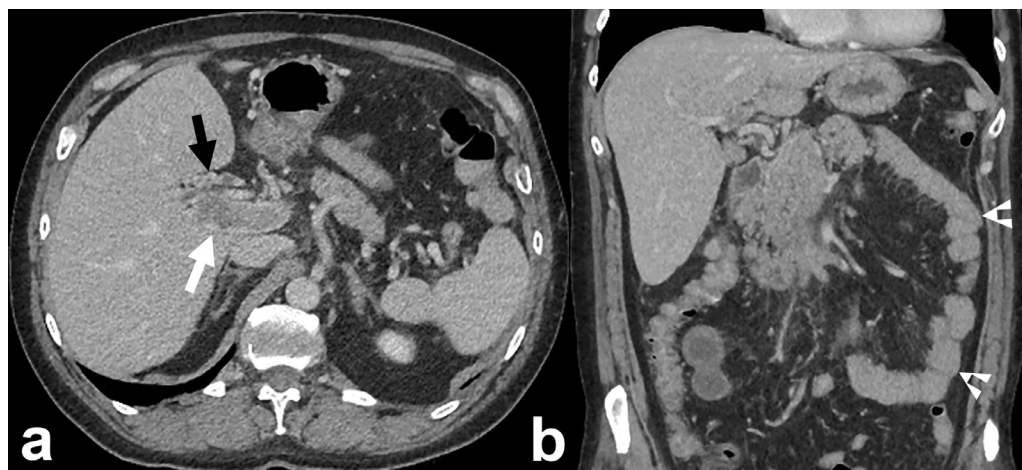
(A) Unchanged extensive portal vein thrombosis (white arrow) in the CT after 48 hours. (B) Regression of congestion-related segmental swelling of small intestine loops (white arrowheads) located in the left lower abdomen.
